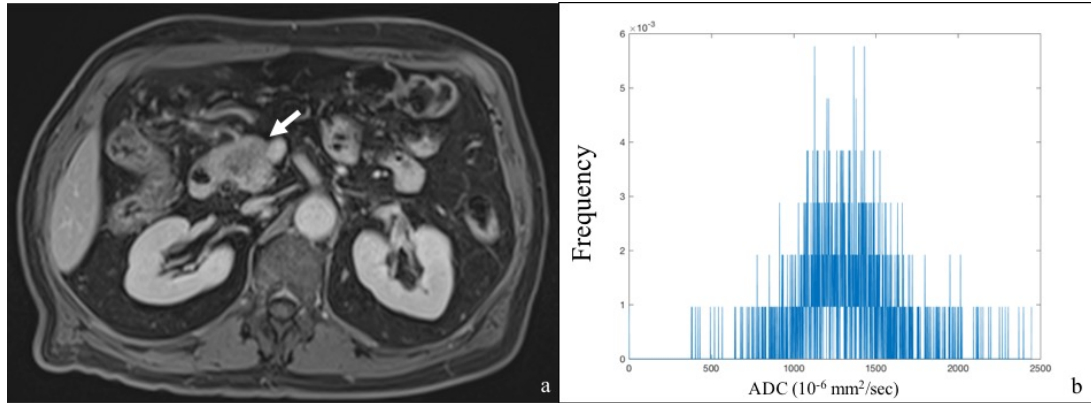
Findings in a 62-year-old man with a ductal adenocarcinoma of the pancreatic head. (a) On axial portal phase T1-weighted image the tumor is homogeneously hypointense; infiltration of the superior mesenteric vein can be seen (arrow). (d) Whole-tumor histogram analysis of ADC values provided high entropy value (7.50).
